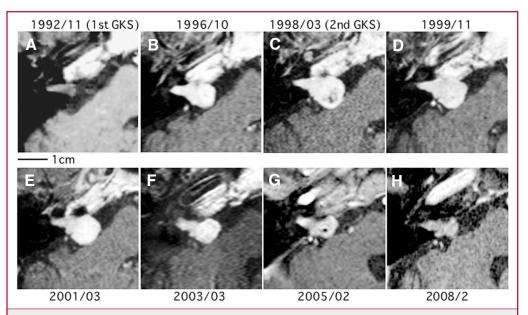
Patient 2, a 58-year-old man with a right vestibular schwannoma (VS), who was followed for the longest follow-up period after repeat gamma knife surgery (GKS). A-H, serial magnetic resonance imaging (MRI) scans obtained from 1992 to 2008. A, MRI scan, 1992. The tumor volume at the initial GKS (peripheral dose, 12 Gy) was 0.1 mL. The tumor continued to grow (B), and the patient underwent repeat GKS (peripheral dose, 12 Gy) (C) 64 months after the first intervention when the tumor volume was 0.54 mL. Tumor regression was continuous (D-G). The tumor volume was calculated as 0.23 mL at the last follow-up examination (121 months) (H).
